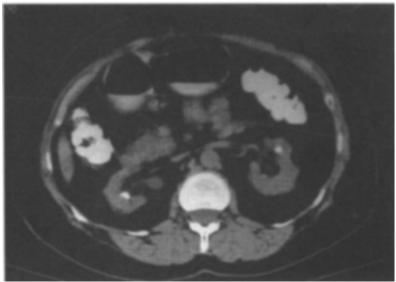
CT scan appearance of analgesic nephropathy in an early stage of renal failure.
